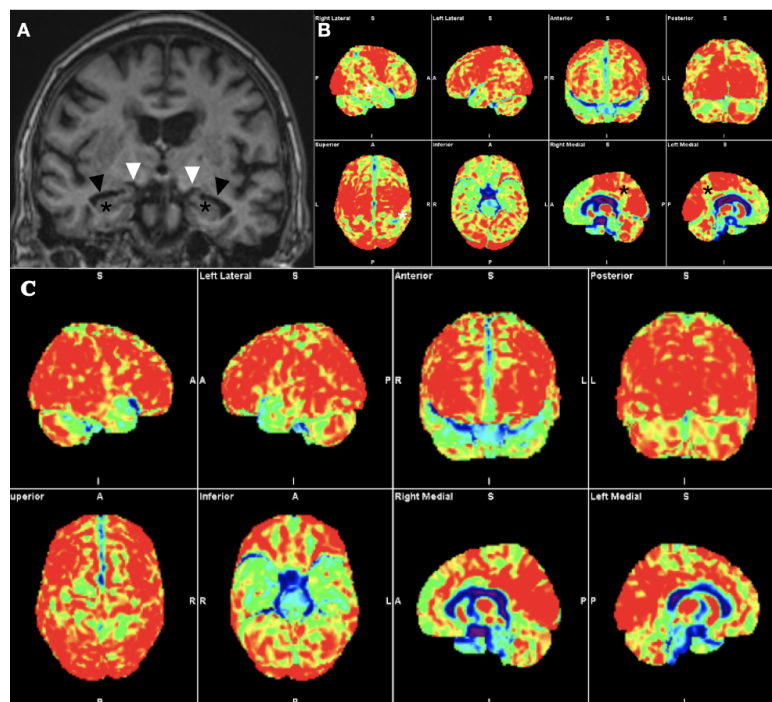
This patient presented with memory difficulties suggestive of mild cognitive impairment or early AD. (A) Coronal volumetric T1-weighted MR imaging through the hippocampi demonstrates widening of the choroidal fissures (white arrows) and temporal horns (black arrows) with minimal reduction in hippocampal size (black asterisks) - MTA 2. (B) 18F-FDG-PET imaging demonstrates subtle hypometabolism in the posterior cingulate gyri (black asterisk) and temporoparietal regions in keeping with early changes of AD. (C) Normal 18F-FDG-PET for comparison purposes.
